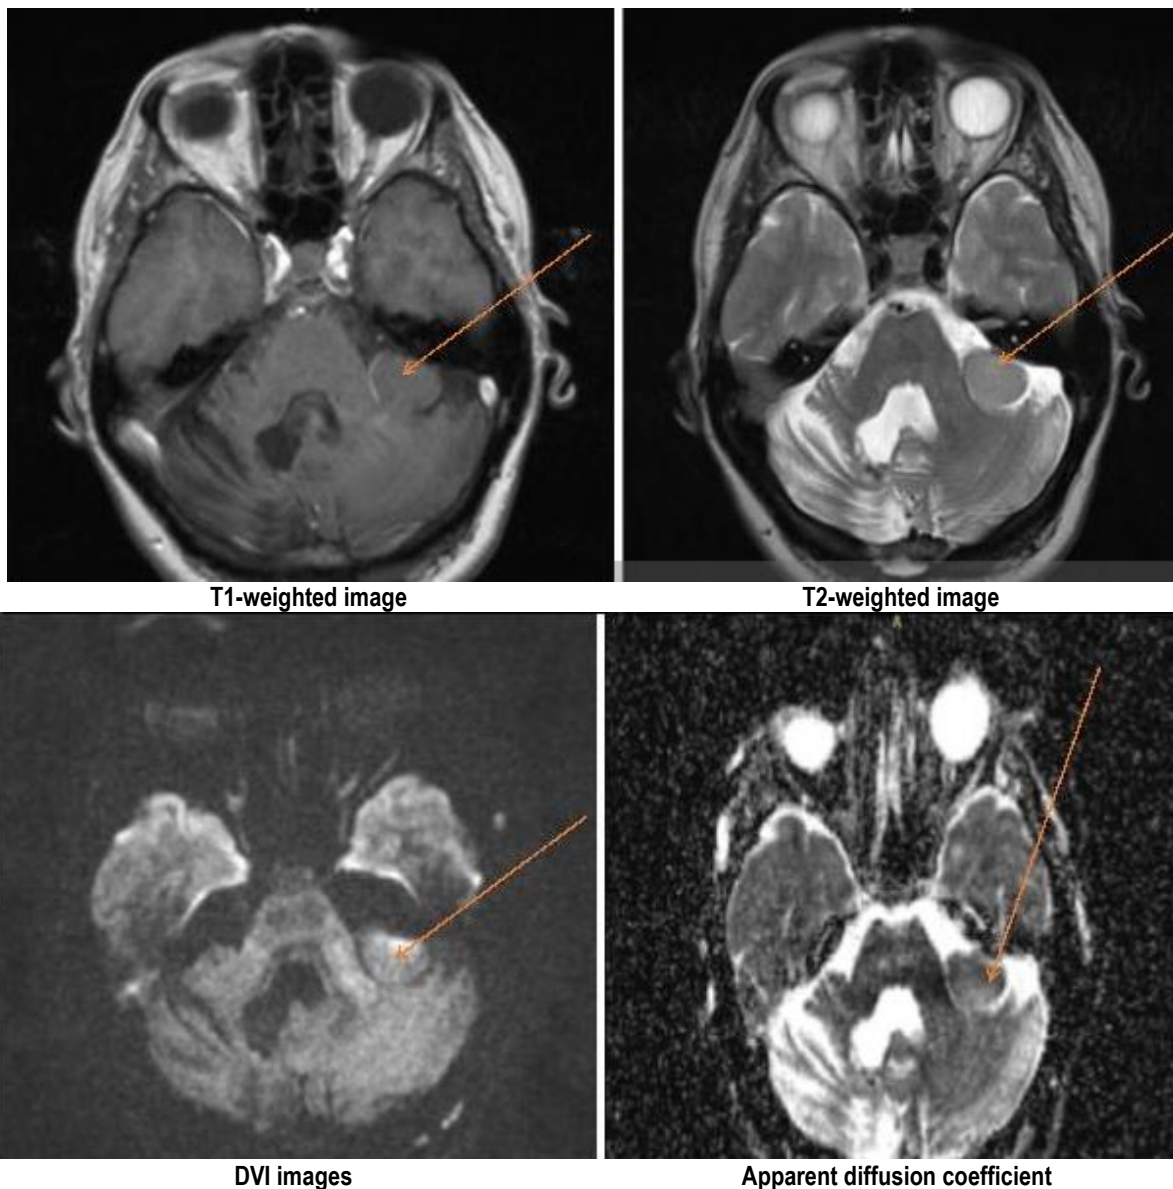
MR imaging of the temporal bone meningioma on the left.
